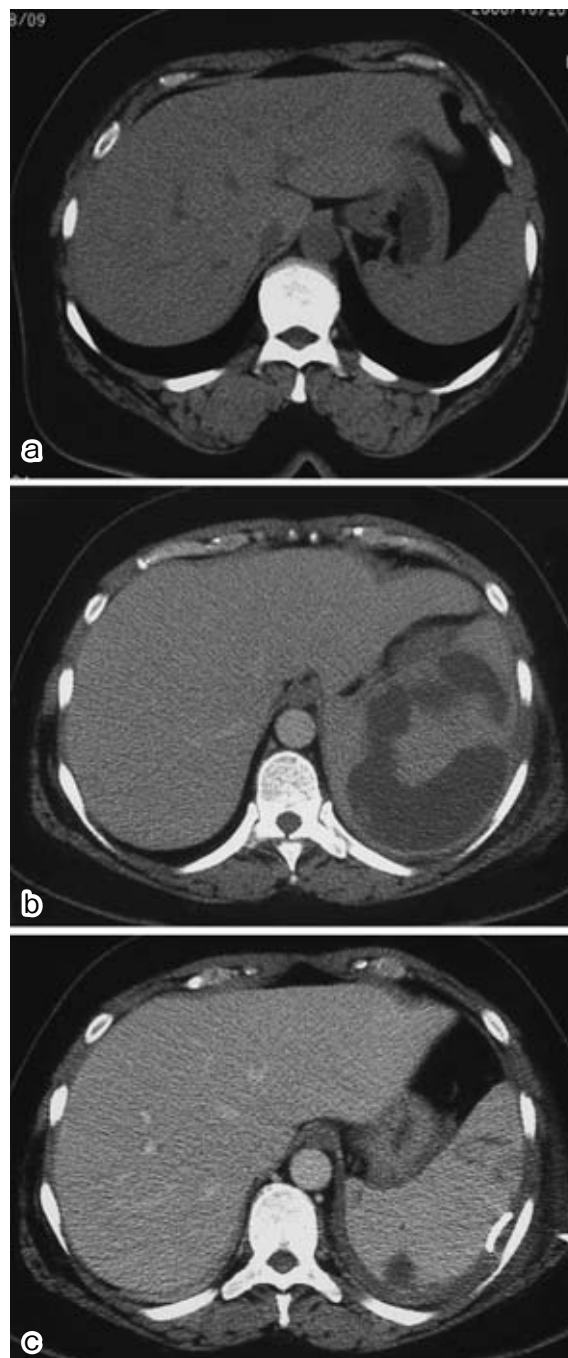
a: Three months earlier, abdominal CT revealed a normal spleen. b: On admission, CT demonstrated a low-density area in the spleen. c: Eleven days after drainage, CT showed that the low-density area had shrunk.
